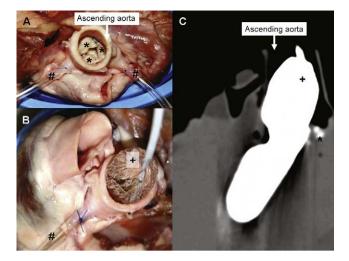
(A) Prepared experimental setup. (B) Insertion of the valvuloplasty balloon (Thyshak II, +). (C) CT scan of the valvuloplasty balloon (+) during procedure (* highly calcified human-aortic leaflets).
